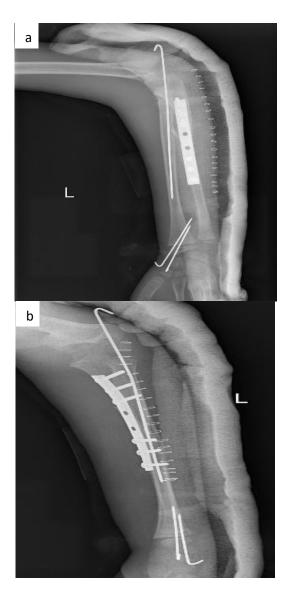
(a, b): X-ray immediate post-op showing good reduction of fracture.
